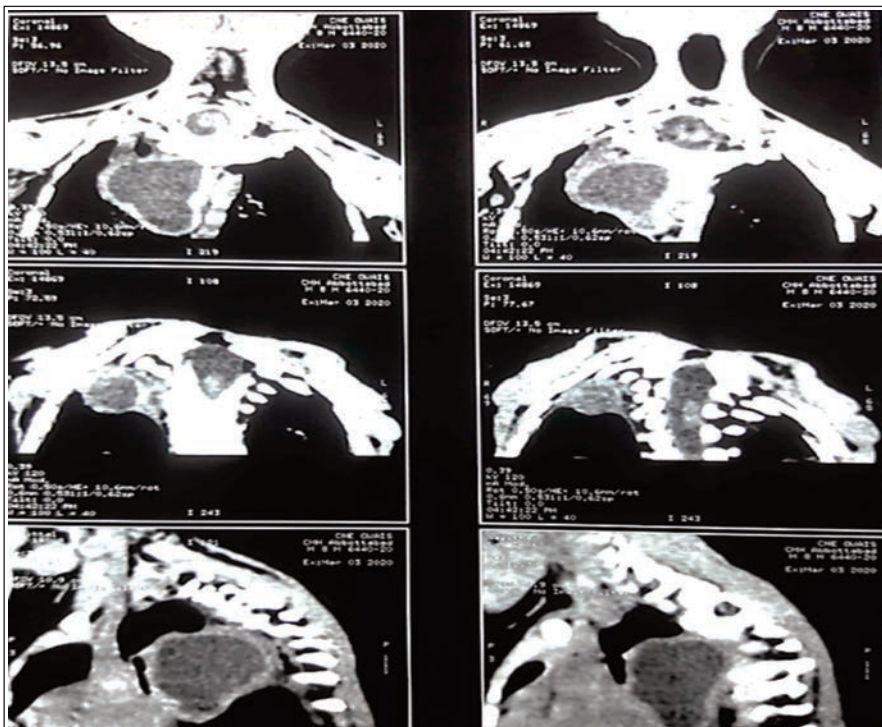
HRCT chest: Showing a large well-defined thick-walled cyst in posterior mediastinum on right side of oesophagus with pressure effects and vertebral anomalies.
